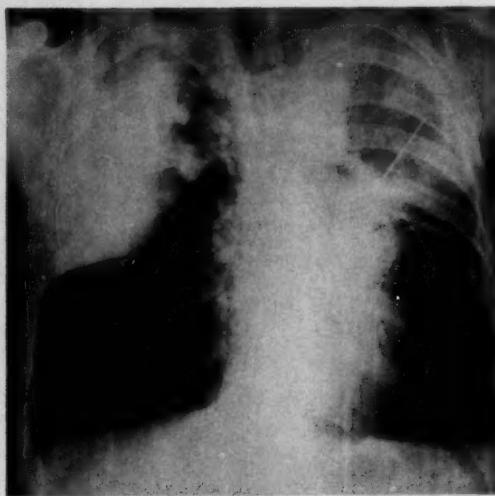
Radiograph showing needle in left pleural space.
